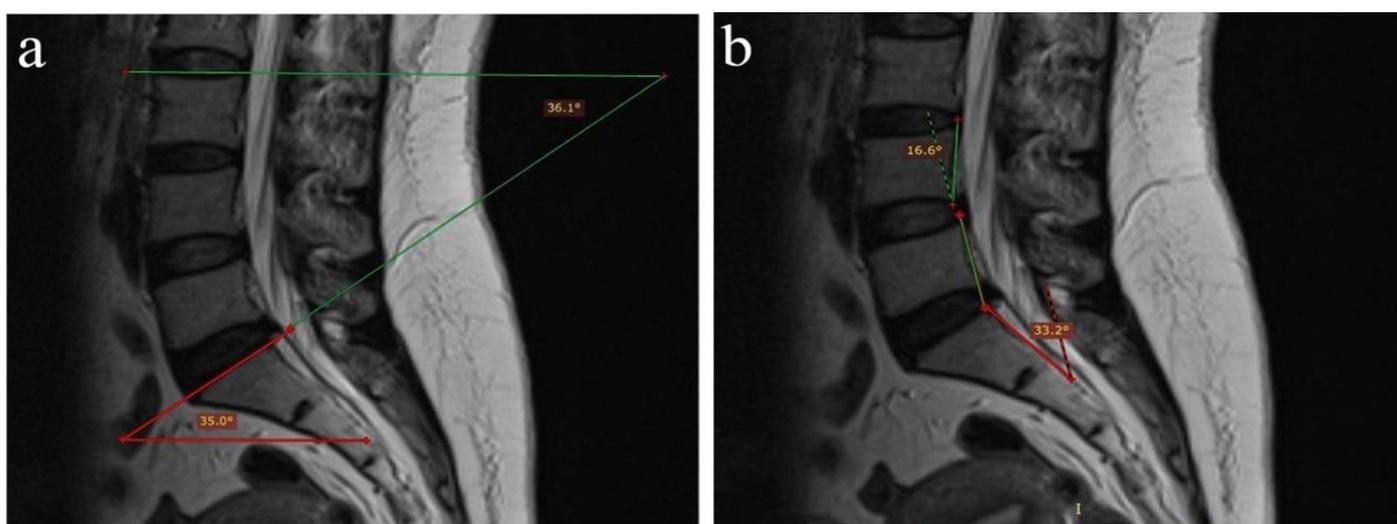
The methods used to measure angles in sagittal MRI (a) A-angle is 35.0° and the B-angle is 36.1°; (b) The largest angle formed by the lines is C-angle = 32.2°
